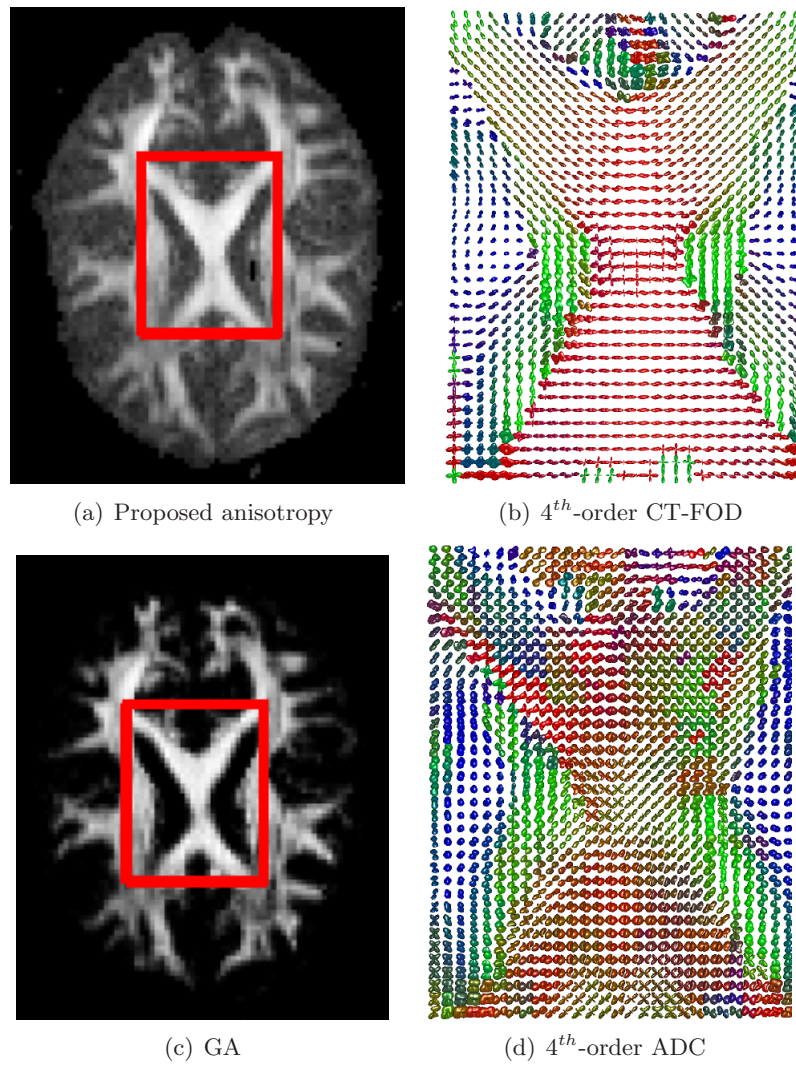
4th-order CT-FOD and ADC tensor fields computed from human brain slice and their corresponding anisotropy measures.
